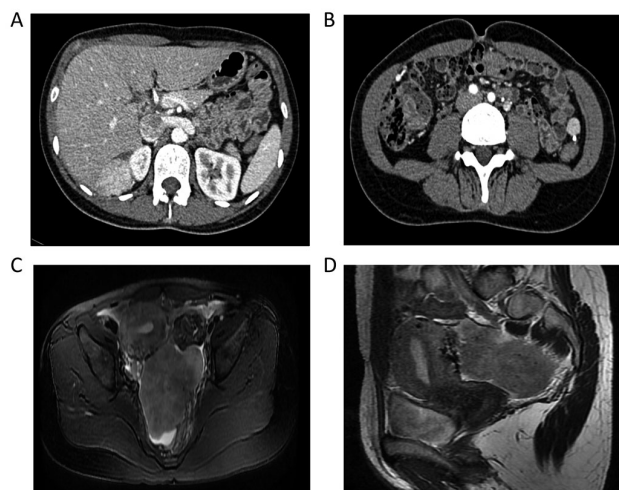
CT and MRI view of case 1. (A) transverse view of CT of the upper abdomen before treatment. (B) Transverse view of CT of the middle abdomen before treatment. (C) Transverse view of MRI of the pelvic cavity before treatment. (D) Sagittal view of MRI of the pelvic cavity before treatment.
